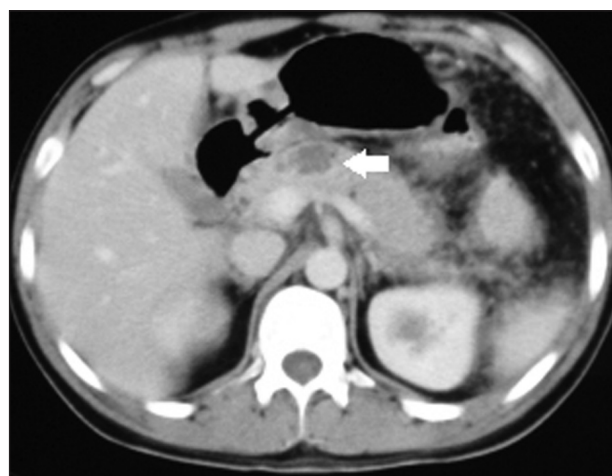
Contrast enhanced computed tomography showing less than 30% pancreatic necrosis (arrow)
